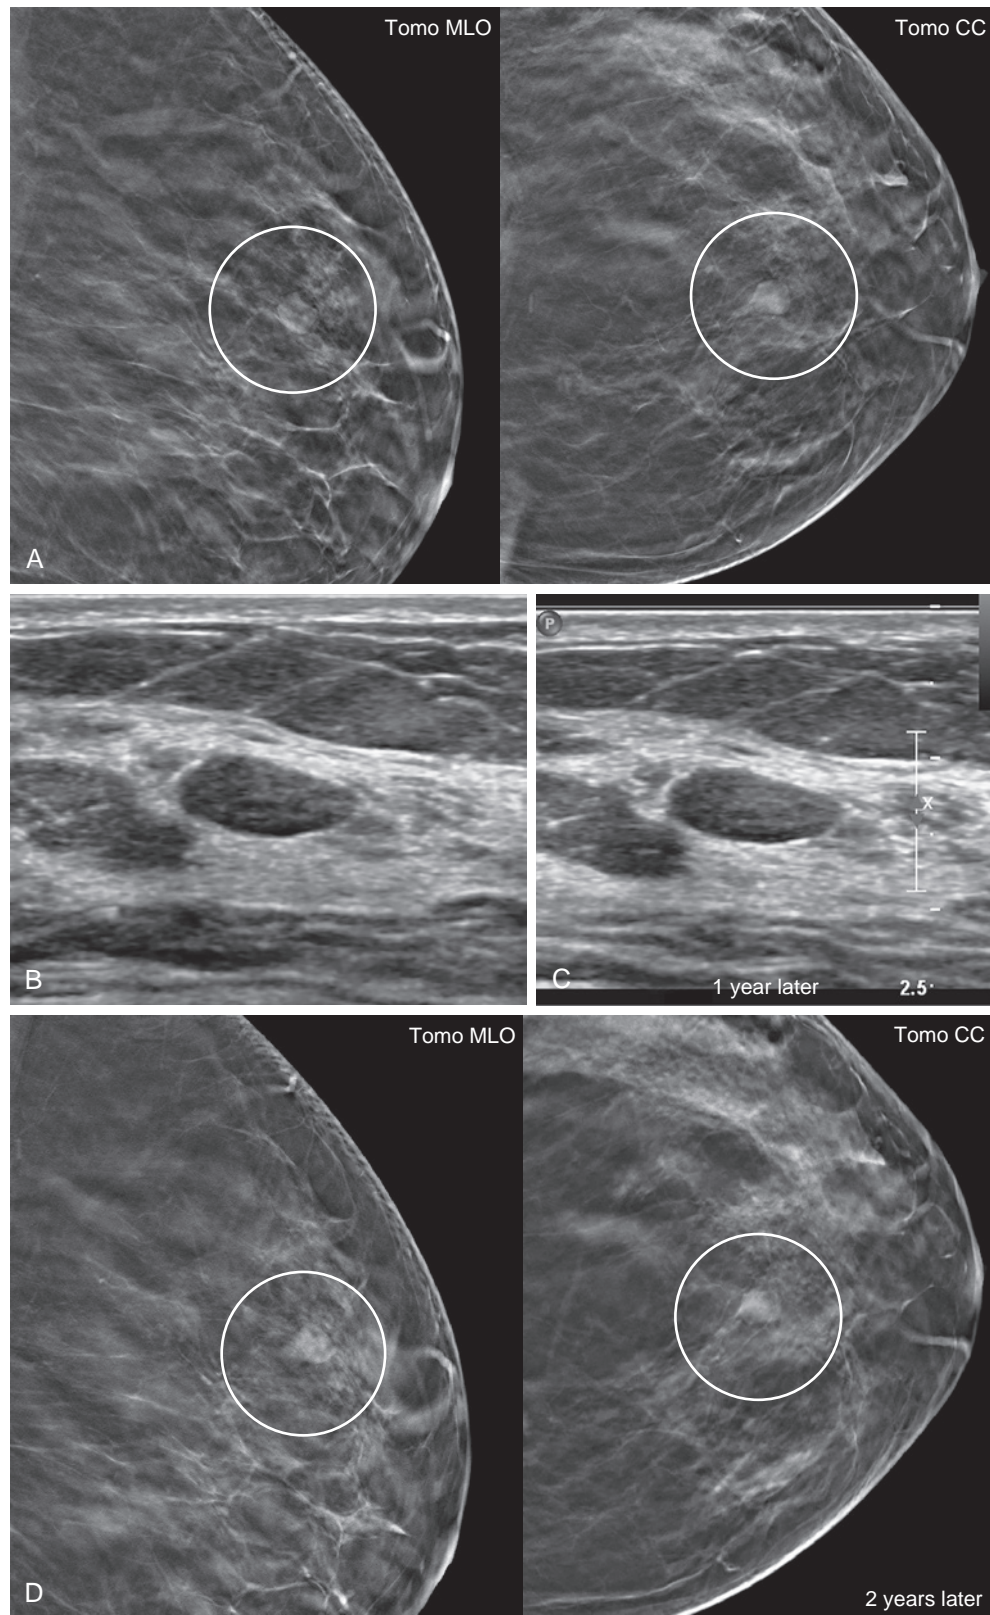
Stable fibroadenoma. (A) A 43-year-old woman was found to have a benign-appearing, oval, circumscribed mass in the left breast seen on mediolateral oblique and craniocaudal tomosynthesis images (*circles*) and (B) ultrasound. (C) An ultrasound 1 year later was stable. (D) On annual mammography, 2 years later, the mass (*circles*) is seen to be completely unchanged on tomosynthesis images, precluding the need to repeat ultrasound. Benign mass shape, size, and margins can be better assessed on tomosynthesis imaging, reducing the need for extended follow-up.
